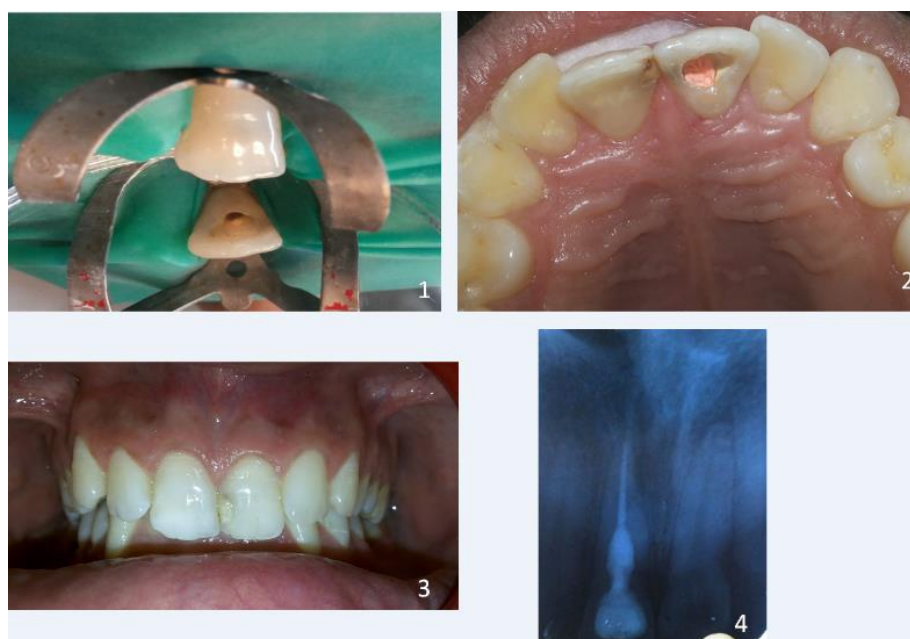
1 Access cavity preparation; 2. Post operative palatal view; 3. Post Operative facial view; 4. Post operative radiograph.
